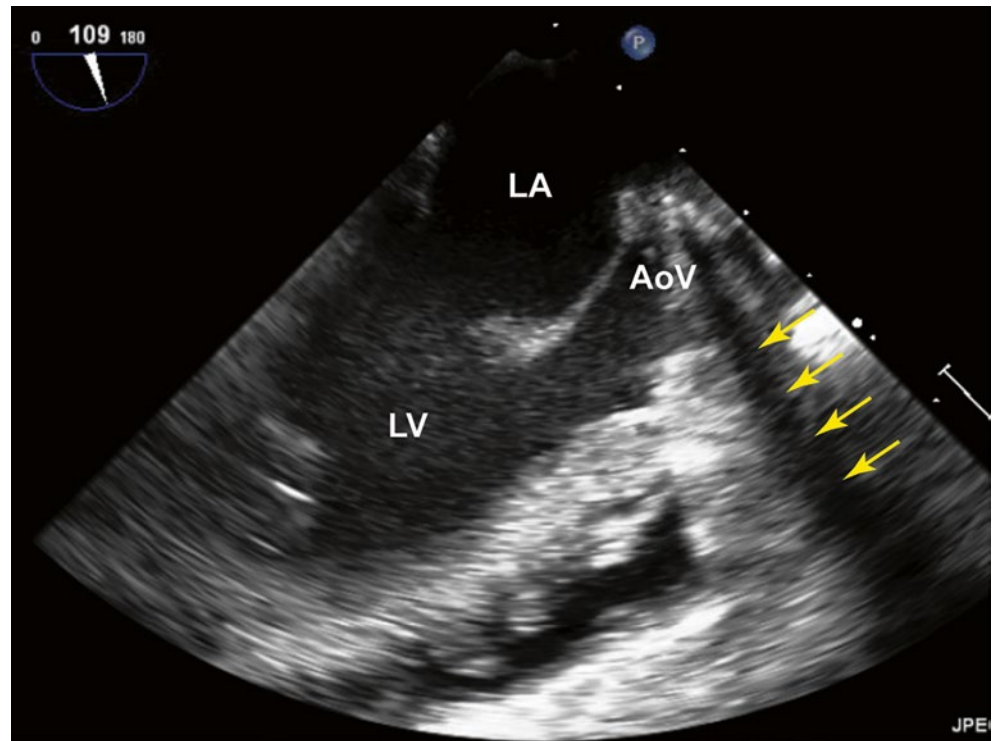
Acoustic shadowing in a patient with a mechanical prosthetic aortic valve (AoV), as viewed from the transesophageal mid esophageal long axis view. The metal prosthetic ring causes significant acoustic impedance mismatching, such that no sound is transmitted beyond that point and a dark, anechoic wedge of shadowing is produced (yellow arrows). Reverberation is also present. LA left atrium, LV left ventricle
